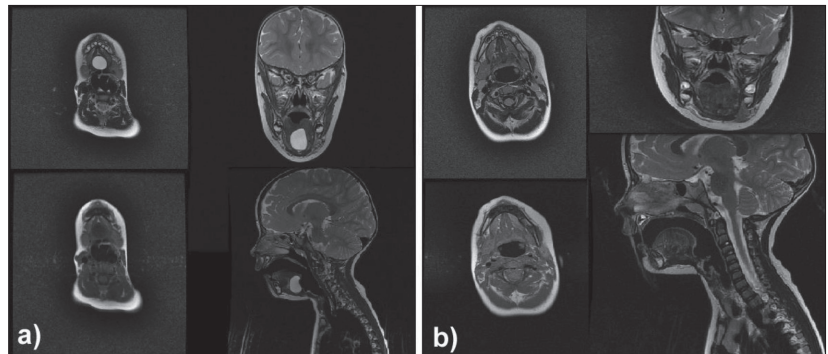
a) Magnetic resonance imaging (MRI) visualisation of the thyroglossal duct cyst; b) MRI of the surgical area after one year of follow-up
